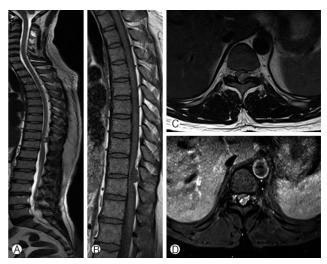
Magnetic resonance imaging of spine. (A) Sagittal T2weighted image shows extradural lesion opposite to D10-11 intervertebral disc space with attachment towards ligamentum flavum. (B) Sagittal T1 contrast weighted imaging showing minimal peripheral contrast enhancement. (C) Axial T2-weighted image shows iso- to hypointense lesion compressing the cord extradurally arising from left synovial joint.
